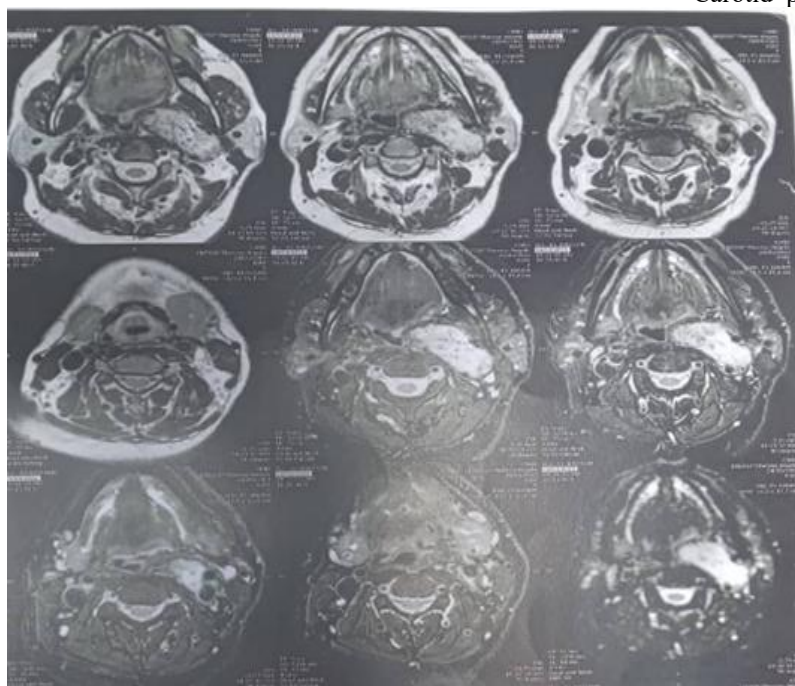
MRI of carotid paraganglioma
